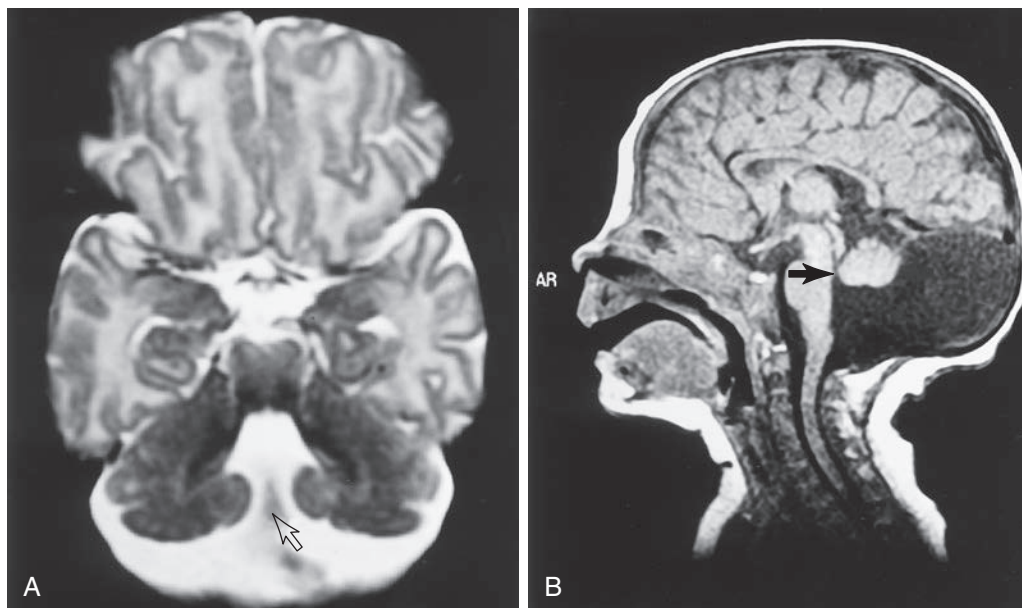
Axial T2-weighted image through the posterior fossa (A) demonstrates the high-signal cerebrospinal fluid in the posterior fossa cyst, which communicates with the fourth ventricle more anteriorly (open arrow). Midsagittal T1-weighted image (B) demonstrates a Dandy-Walker variant in this patient. The partial formation of the vermis seen best on the sagittal image defines a Dandy-Walker variant (black arrow).
